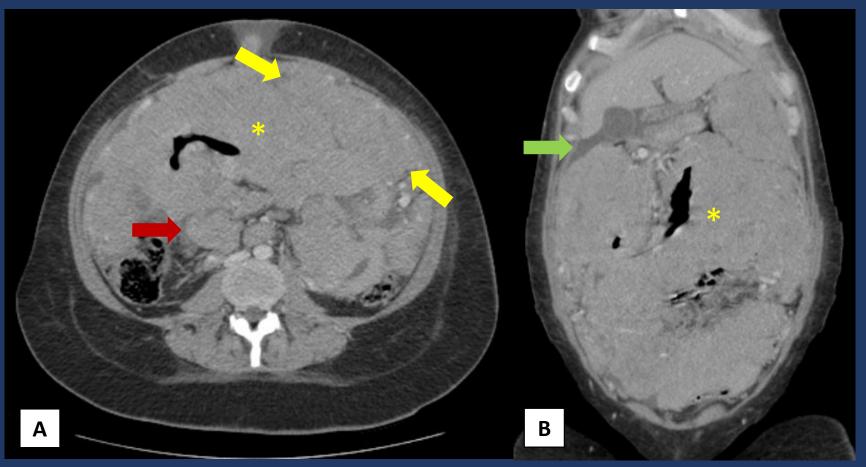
Axial (A) and coronal (B) CT images shows exuberant diffuse parietal thickening of several intestinal small loops (asterisk), difficult to be individualized from each other, with patent lumen, proved to be lymphoma. Note the associated multiple bulky adenopathies (red arrow), omental cake (yellow arrow) and small ascites (green arrow), signs of <u>peritoneal lymphomatosis</u>, a rare entity.
